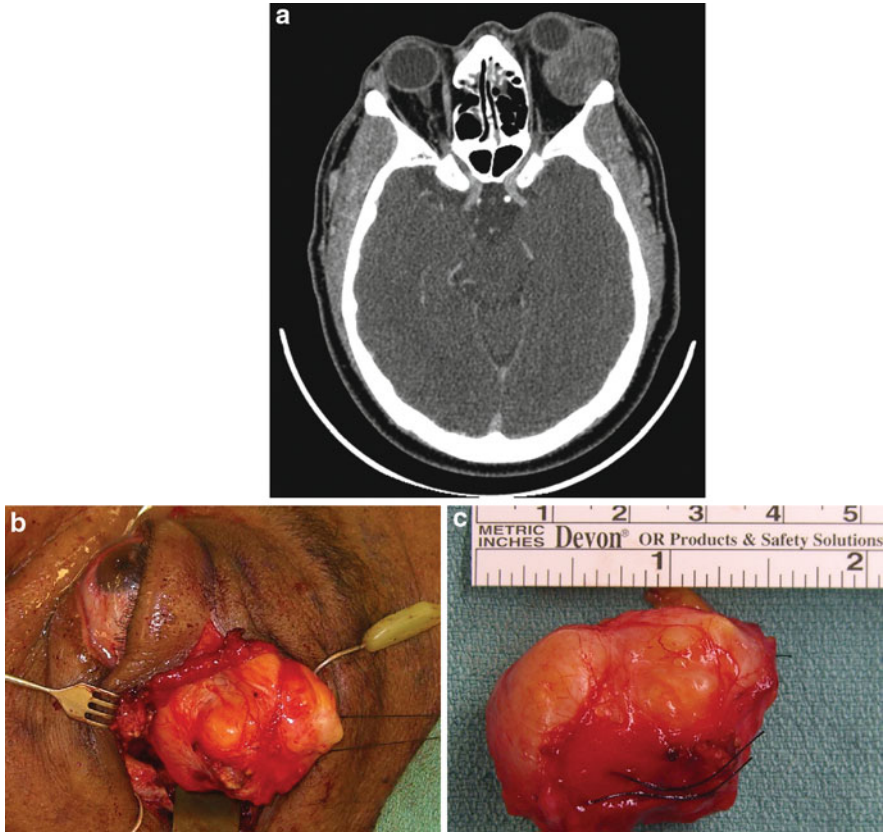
(a) Computed tomography image of a patient with a large pleomorphic adenoma of the lacrimal gland. (b) En bloc surgical resection of a pleomorphic adenoma of the lacrimal gland through a lateral orbitotomy and bone flap. (c) The lesion was excised with its pseudocapsule intact. Figures courtesy of Dr. Bitu Esmali
